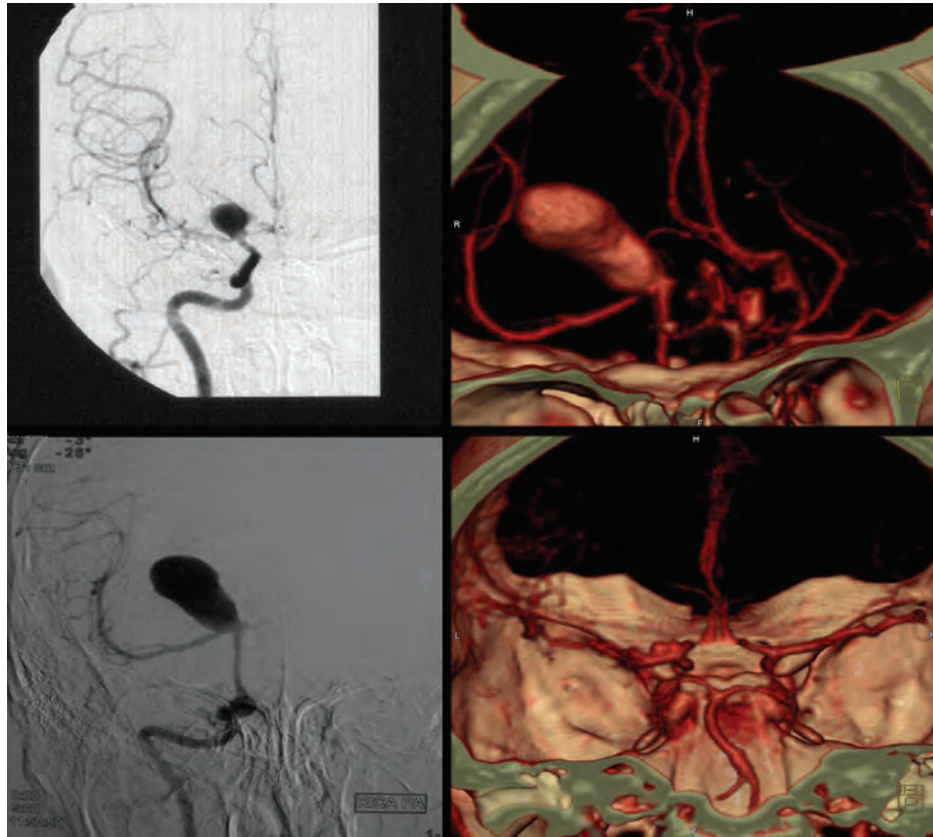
CTA and DSA showing a large left ICBA
